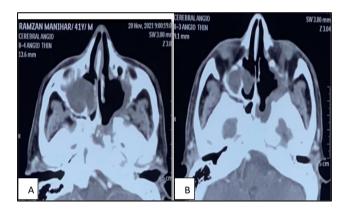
(A and B): CT angiogram showing aneurysm in the petrous segment of ICA.
